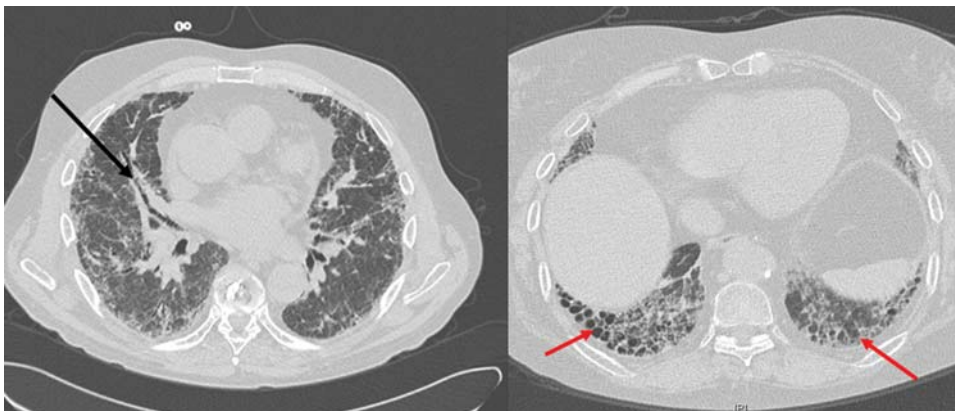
FIGURE e24-17 CT scan of usual interstitial pneumonitis (UIP), also known as idiopathic pulmonary fibrosis (IPF). Classic findings include traction bronchiectasis (*black arrow*) and honeycombing (*red arrows*). Note subpleural, basilar predominance of the honeycombing.
